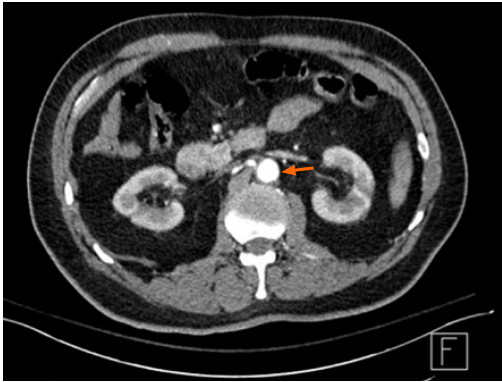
Computed tomography angiogram of the abdomen- portrays a patent aorta with contrast visualized just prior to the complete thrombotic occlusion.
